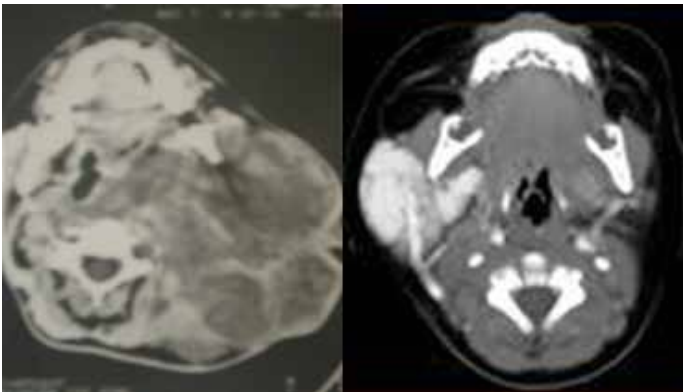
CT scan of neurofibroma pushing the airway in a 16-year-old girl.
